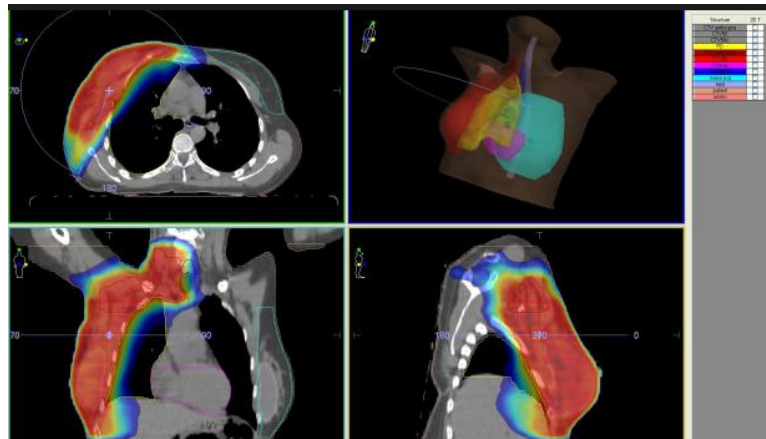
Example of CT with dosimetry
